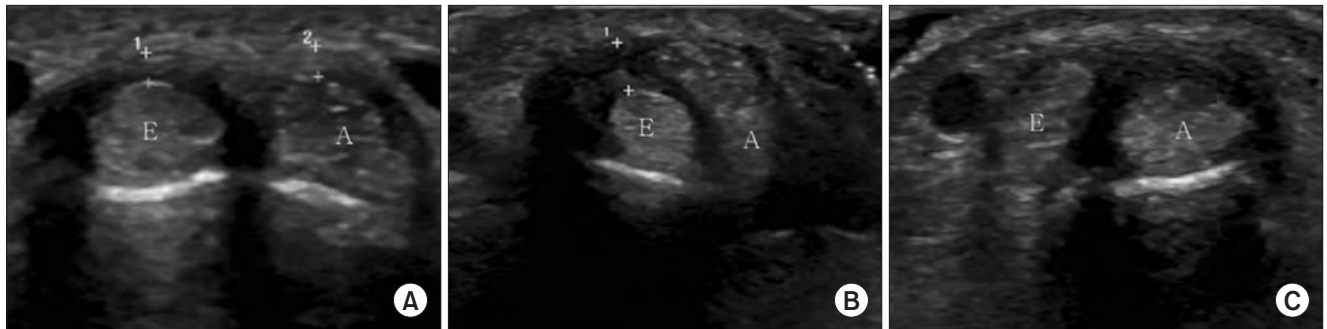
The sonographic images provide a detailed representation of the first extensor compartment of the wrist, specifically focusing on instances of selective and non-selective stenosis in either or both subdivisions of the first dorsal compartment. E: extensor pollicis brevis, A: abductor pollicis longus. (A) The “non-selective stenosis” section of the image shows instances where stenosis is not selectively affecting either the abductor pollicis longus or extensor pollicis brevis, but rather is present in both tendons. (B) The “extensor pollicis brevis stenosis” section of the image shows selective stenosis predominantly affecting the extensor pollicis brevis alone. The thickness between the ‘+’ signs represents extensor pollicis brevis hypertrophy. (C) The “abductor pollicis longus (APL) stenosis” section of the image shows selective stenosis in the APL alone, which was observed in very few patients in this study.
